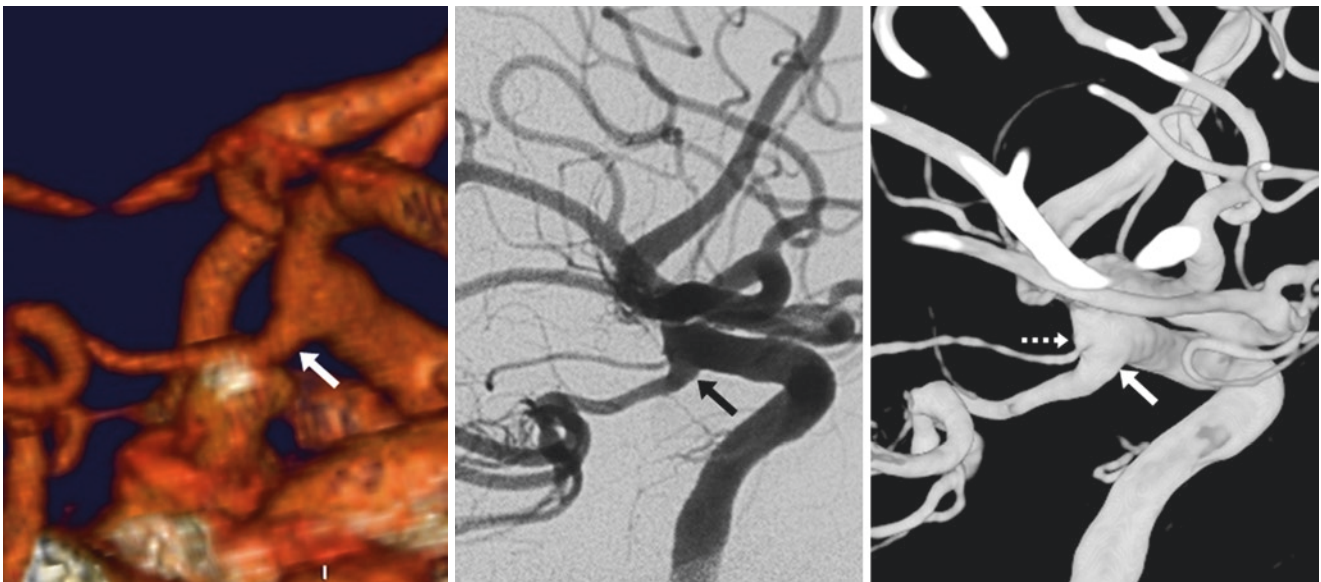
In this 46-year-old, a 3D VR CTA lateral view (*left*) shows an infundibular outpouching (*arrows*) of the PcoA origin, with a prominent PcoA. Lateral views from both DSA (*middle*) and 3DDSA (*right*) confirm that the vessel arises from the apex. Note a tiny anterior choroidal artery infundibulum (*dotted arrow*) distally on the 3DDSA
